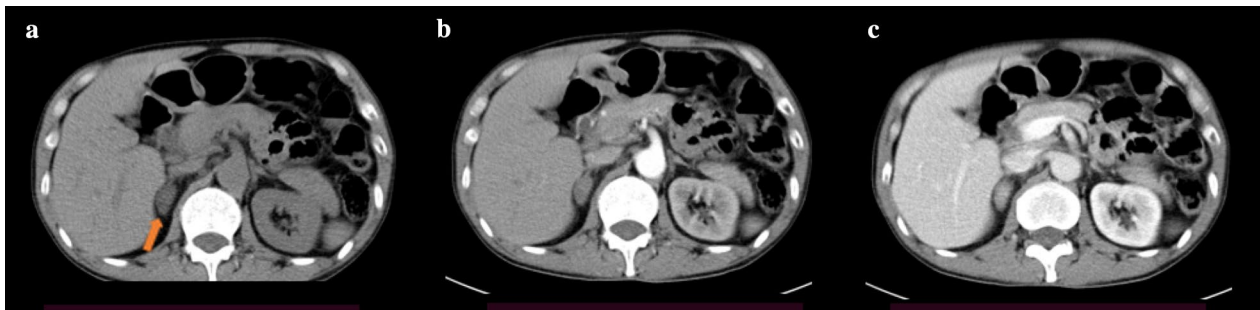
A surgery-proven ganglioneuromas in a 42-year-old patient. a Unenhanced CT image showed a round-shaped nodule with a mean size of 15 mm from right adrenal (arrow). The CT value of unenhanced was 38 HU. b, c Enhanced CT images depicted that the CT value of arterial phase, and venous phase was 42, and 47 HU, respectively
